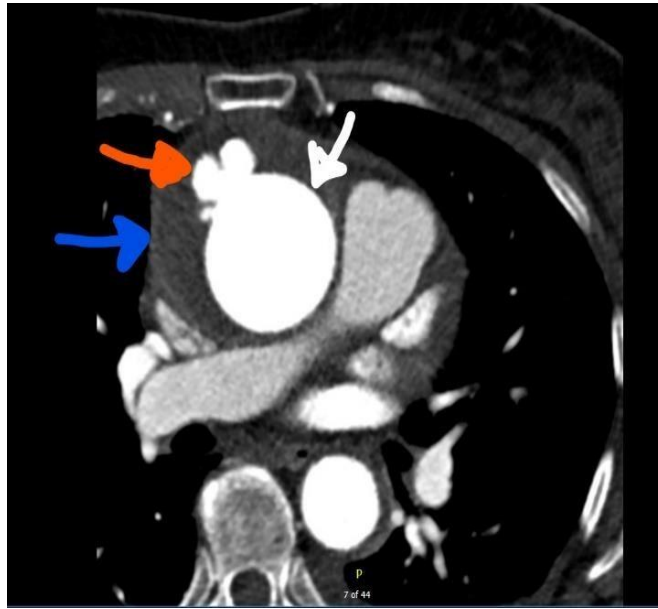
CT scan showing multiple PAUs and IMH of the ascending aorta, white arrow points to ascending aorta, red arrow points to PAUs, blue arrow points to IMH
